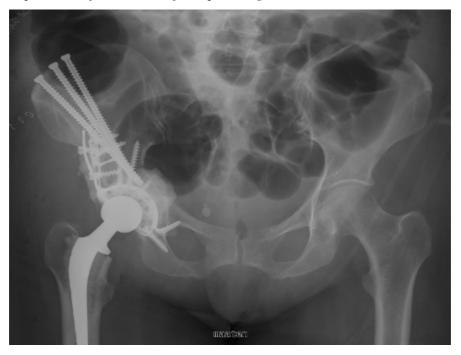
Radiograph showing the reconstruction achieved with three full-threated screws, reinforcement cup and of the cemented acetabular component with cemented femoral stem.
